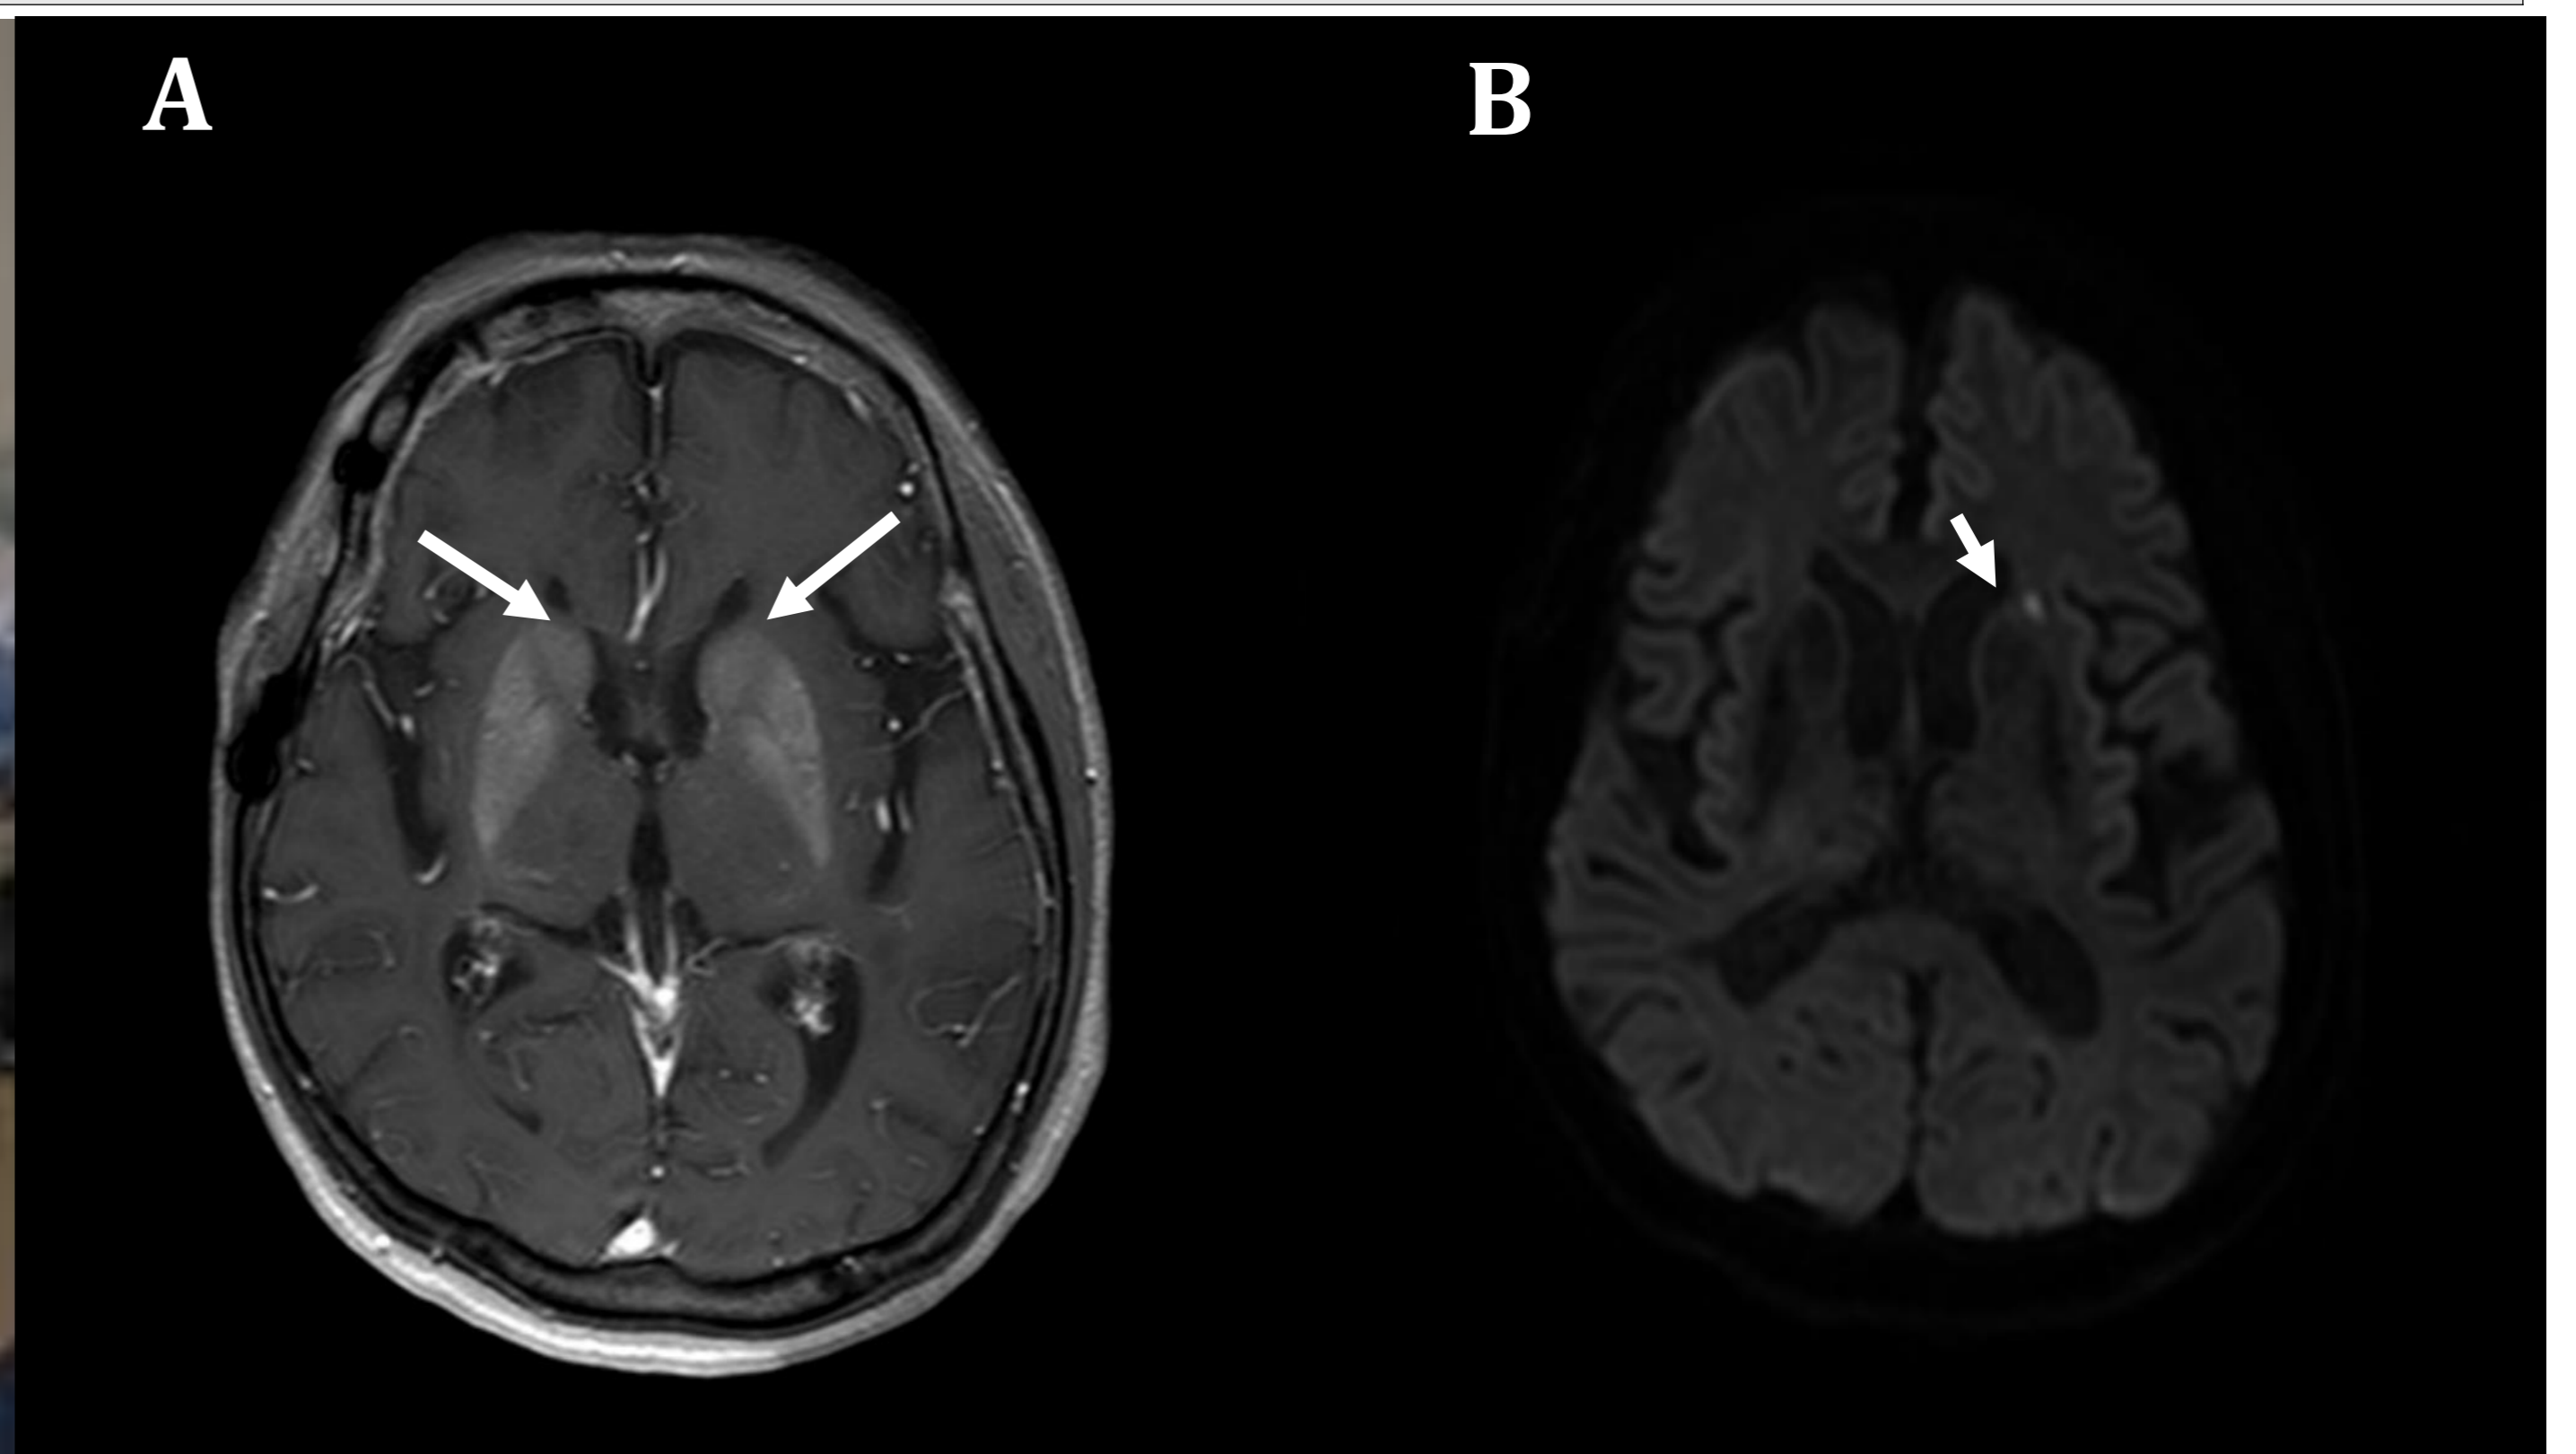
(A) Bilateral striatal hyperintensity axial T1-weighted imaging(arrows) (B) Small focal hyperintense lesion in the left basal ganglia(white arrowhead) on diffusion-weighted imaging
